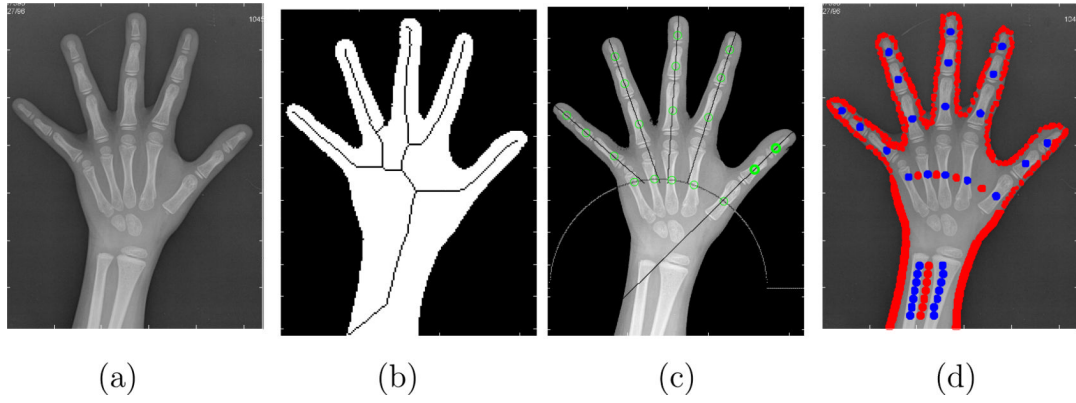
Automatic method for the location of the training points in the radiograph: (a) Original image; (b) Skeleton of the hand silhouette; (c) Location of the training regions inside the phalanges; (d) Final training regions for bones (blue) and soft tissue (red).
